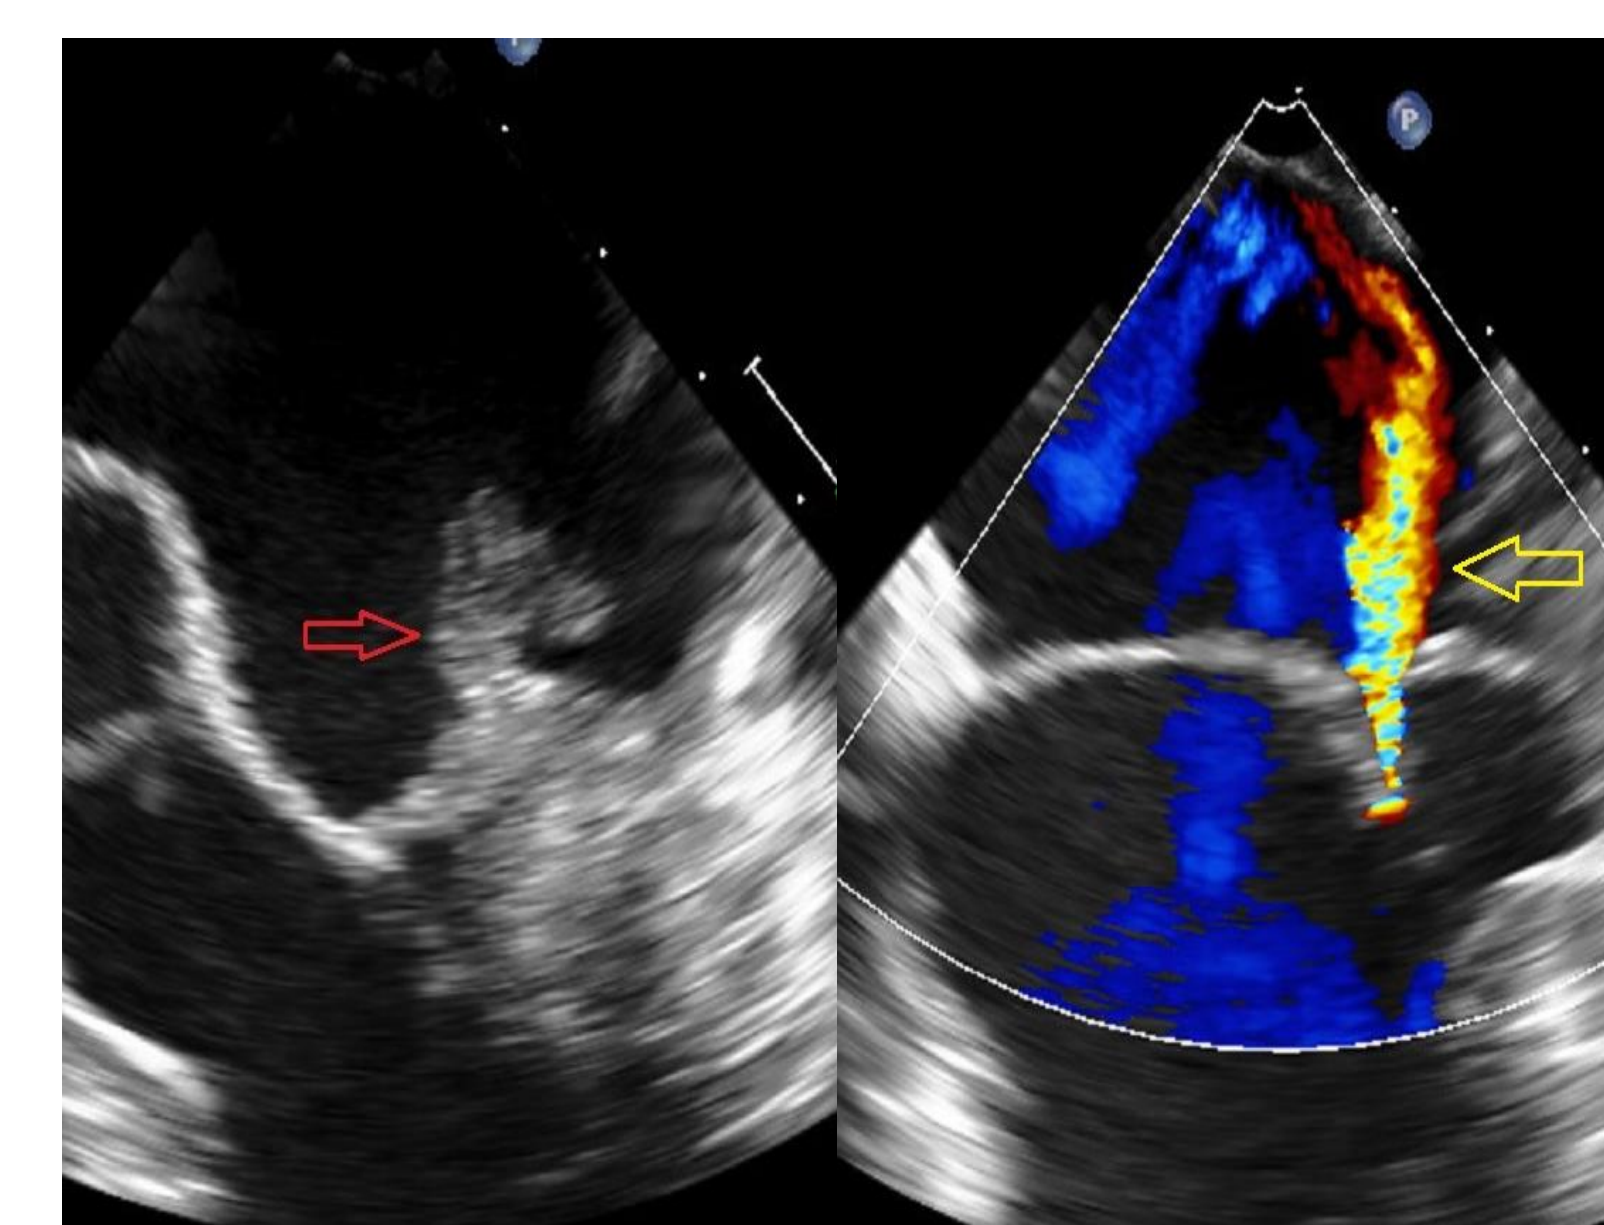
Patient A – Transoesophageal echocardiogram showed an irregular, frond-like shaped mass (red arrow) attached to the posterior mitral leaflet with associated lateral mitral regurgitation. The mass measured 1.5 x 1.0cm and was associated with mild-moderate mitral regurgitation (yellow arrow).
